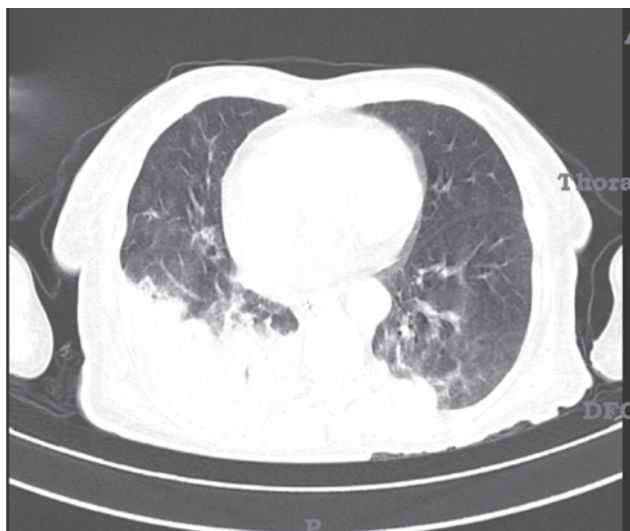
CT scan chest showing collapse consolidation of right lower lobe.
